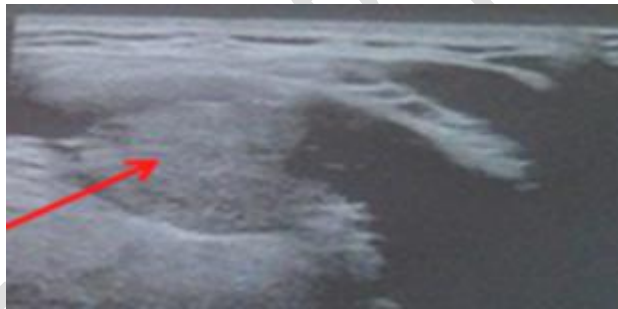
Ultrasonography (USG) of the neck showing absence of thyroid tissue
